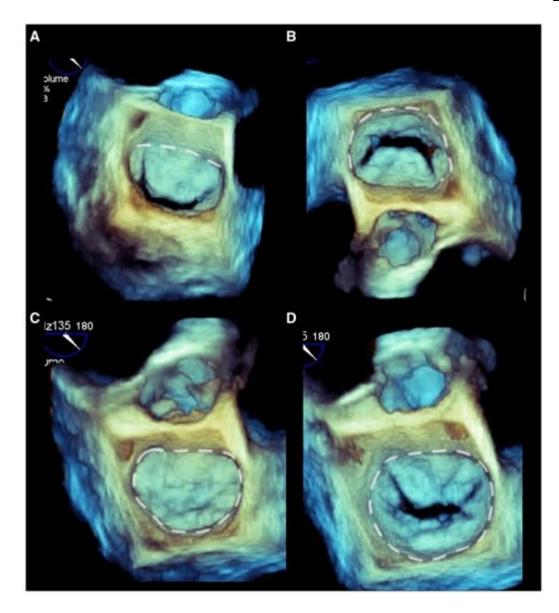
A 3-dimensional transesophageal echocardiogram of mitral valve in a healthy adult. (A) The surgical view shows a dotted line that is straight anterior mitral annulus. (B) The C-shaped posterior mitral annulus is marked by a dotted line when viewed from an anterior angle. (C) Surgical view during mid-systole exposes a D-shaped annulus. (D) The circular appearance of the mitral annulus in mid-diastole (Faletra et al., 2019)
